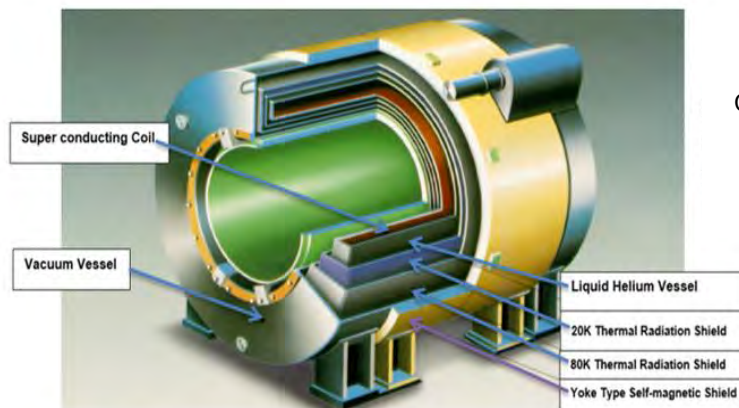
Section of Super-Conducting magnet MRI (Curtsey of Basic MRI physics; Evert J Blink Application Specialist MRI PP.7)
